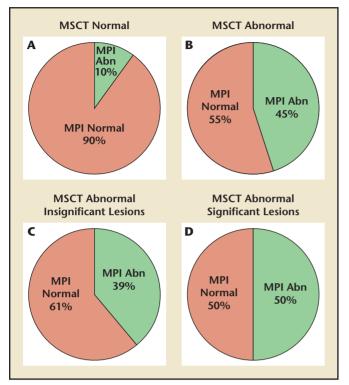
Relation between multislice computed tomography (MSCT) and myocardial perfusion imaging (MPI). (A) The 90% of MSCT patients with normal images had a normal MPI. (B) Only 55% of patients with an abnormal (Abn) MSCT had an abnormal MPI. (C) When the MSCT suggested insignificant epicardial coronary disease, the MPI was abnormal in 39%. (D) When the MSCT suggested significant disease, the MPI was abnormal in half. Data from Schuijf JD et al.¹
